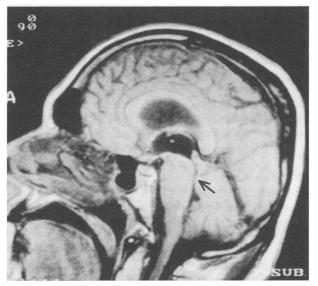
A magnetic resonance image of a patient with coccidioidal meningitis complicated by hydrocephalus shows the third ventricle to be enlarged, but the aqueduct of Sylvius is patent, as indicated by the arrow.
